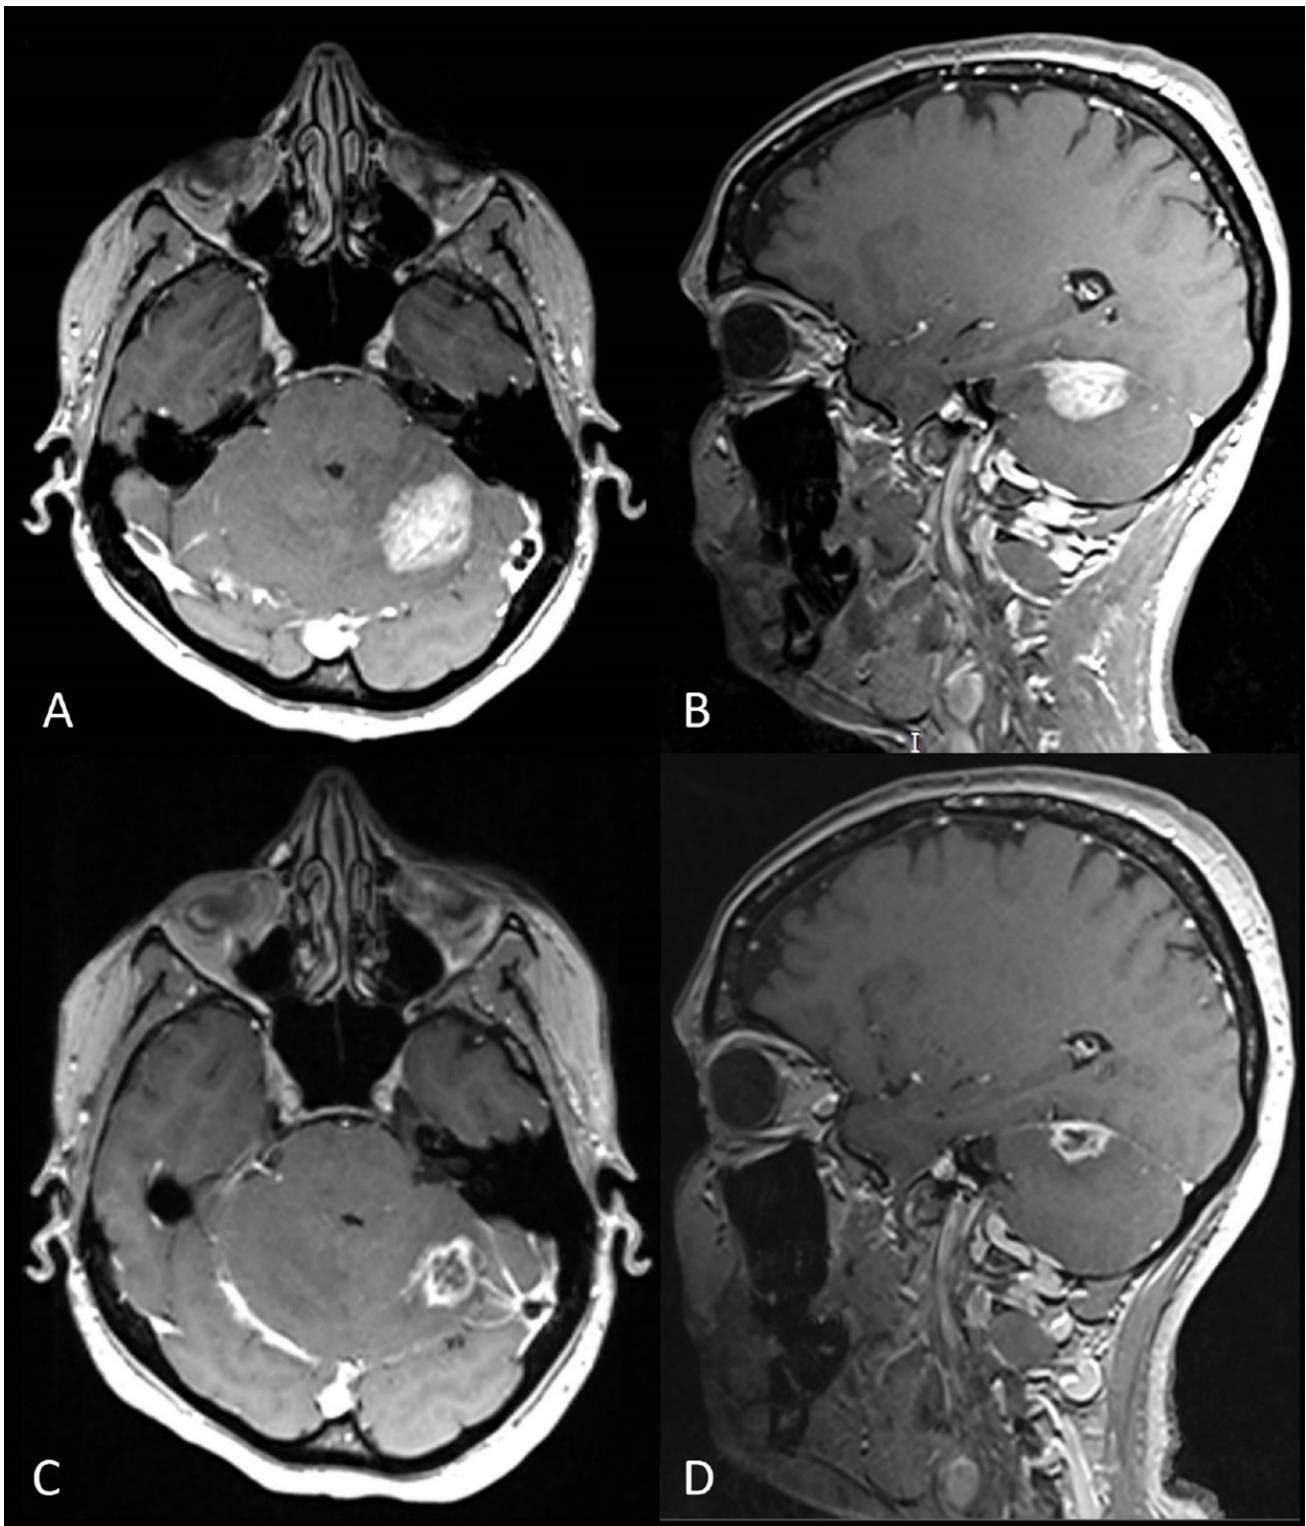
MRI of brain metastasis before and 3 months after SRS in a 57-year-old patient with breast carcinoma. (A) Axial postcontrast T1WI before SRS, (B) sagittal postcontrast T1WI before SRS, (C) axial postcontrast T1WI after SRS, (D) sagittal postcontrast T1WI after SRS. Expansive lesion in the left cerebellar hemisphere with inhomogeneous postcontrast enhancement and edema, with partial response (PR) after SRS.
